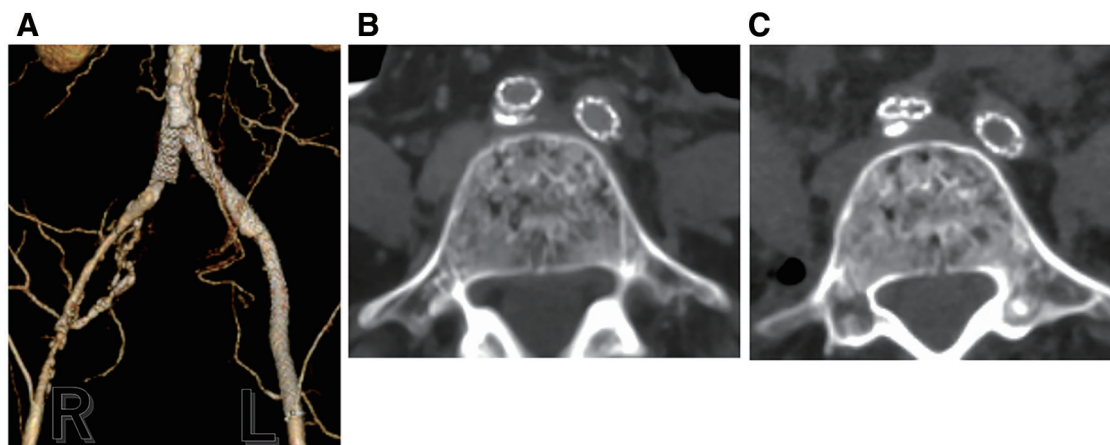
(A) Three-dimensional representation of the outpatient follow-up computed tomography displays a Viabahn VBX 8 mm × 39 mm stent in the right common iliac, a Viabahn VBX 8 mm × 59 mm stent in the left common iliac, and a Viabahn VBX 7 mm × 79 mm stent and Epic 8 mm × 80 mm stent in the left external iliac. The distal segment of the Viabahn VBX stent within the right common iliac artery collapsed, which was accompanied by thrombotic occlusion of the lumen. (B) The pre-ileal surgery CT demonstrated unobstructed dilation of the stent in the right common iliac artery. (C) The post-ileal surgery CT, conducted 1 day later, revealed the collapse of the distal portion of the stent. VBX: Viabahn Balloon-Expandable Endoprosthesis; CT: contrast-enhanced computed tomography
